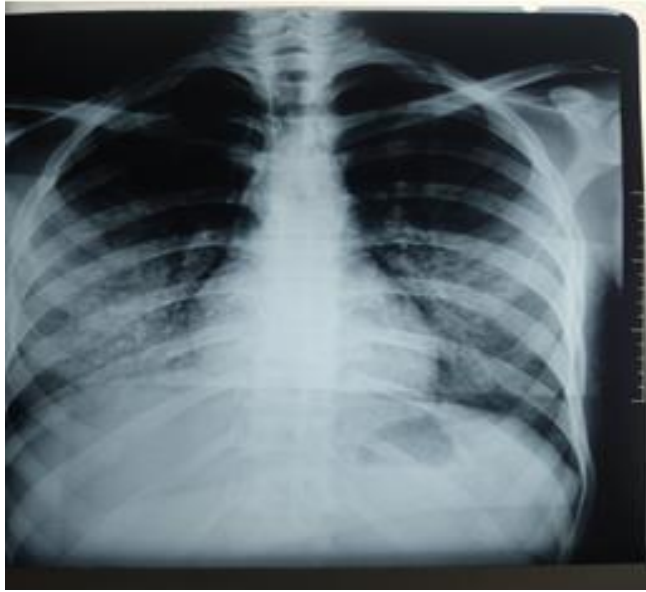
a front chest x-ray showing bilateral alveolar syndrome
